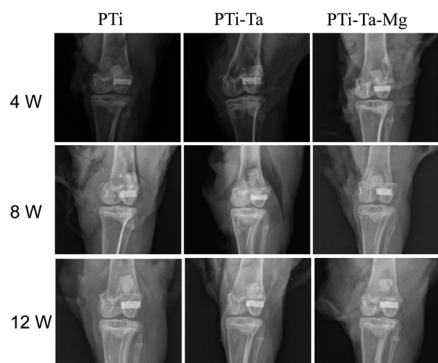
X-ray radiographs of operated femoral condyle harvested at different times.
